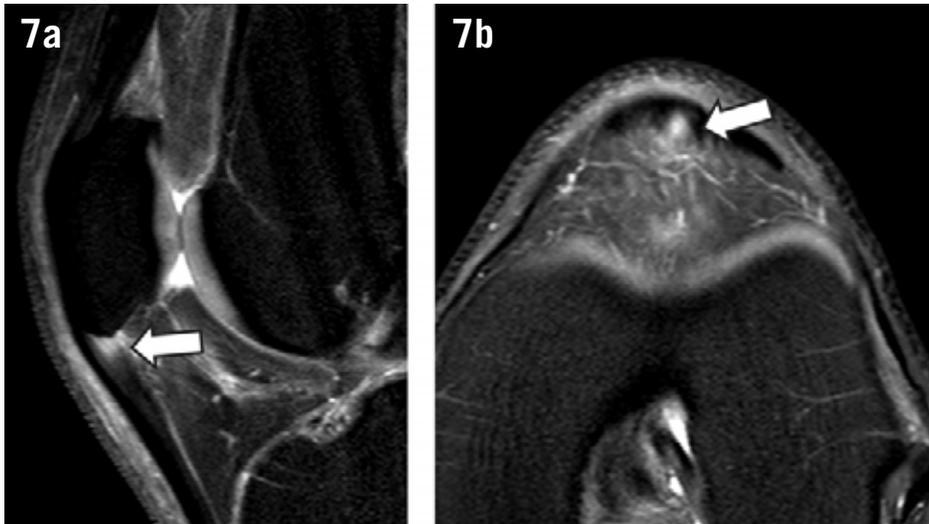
Magnetic resonance imaging indicating patellar tendon tendinopathy with a small partial tear at the origin. Sagittal (a) and axial (b) T2 weighted images with fat saturation depicting increased signal at the origin of the patellar tendon (arrow in a), consistent with tendinopathy, associated with a small area with fluid signal intensity in the deep fibers (arrow in b), related to a focal partial tear.
